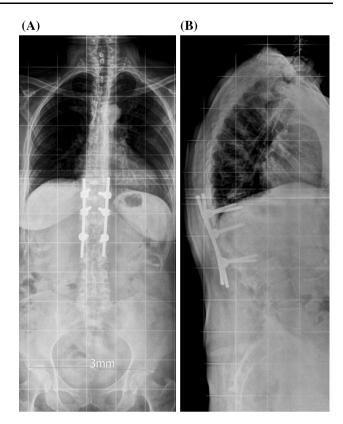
a, b Antero-posterior and latero-lateral X-rays: L1 traumatic collapse treated by posterior stabilization with bars and transpedicular screws at D11, D12, and L2
